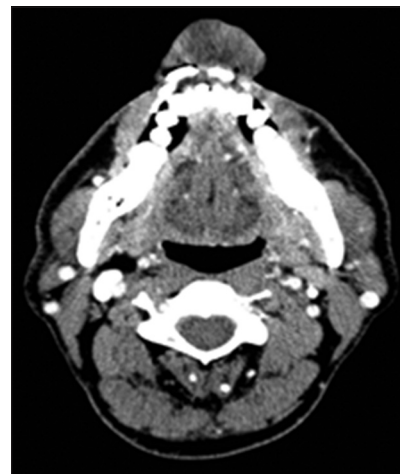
Computed tomography showing an ulcerative lesion involving upper lip measuring 3.5 cm × 3.5 cm × 1.8 cm
